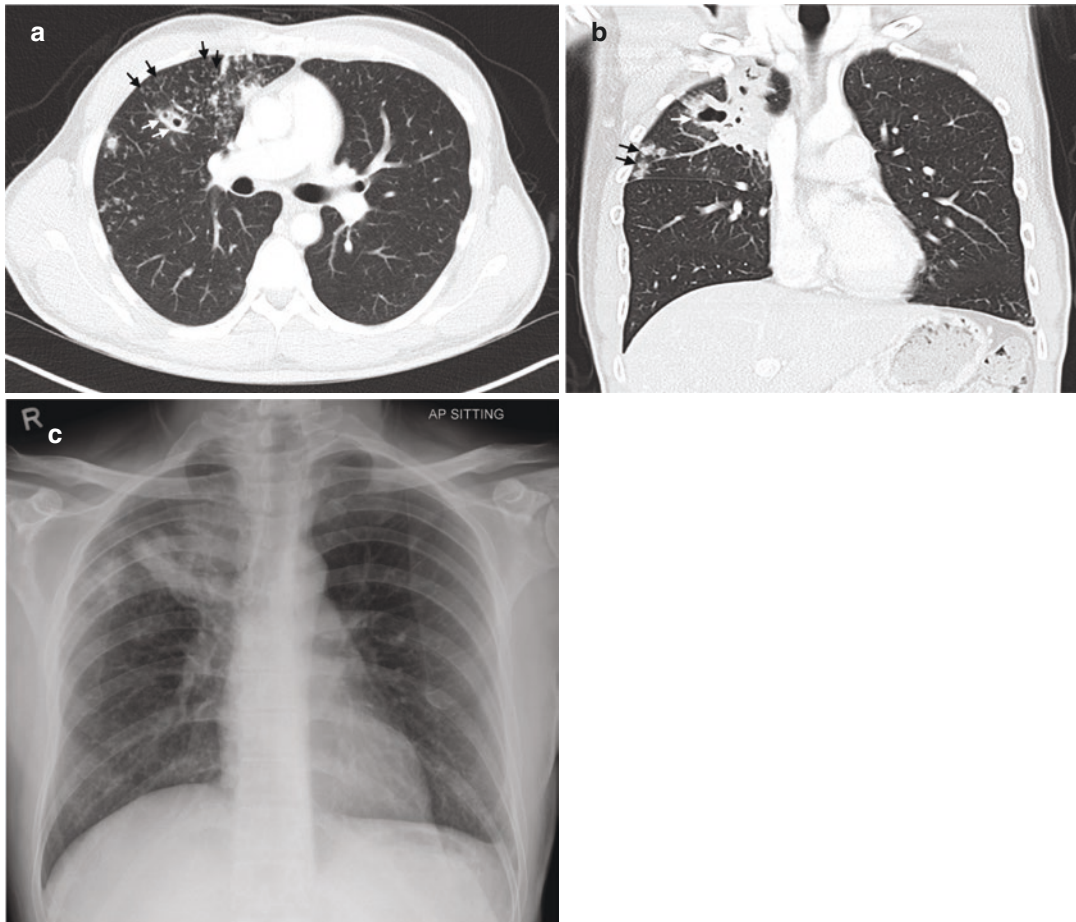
Pulmonary tuberculosis. (a) Axial and (b) coronal CT images taken in the lung window setting. In the right upper lobe, there are areas of consolidation with internal cavitation (white arrows), as well as centrilobular tree-in-bud opacities (black arrows). Sputum cultures confirmed
